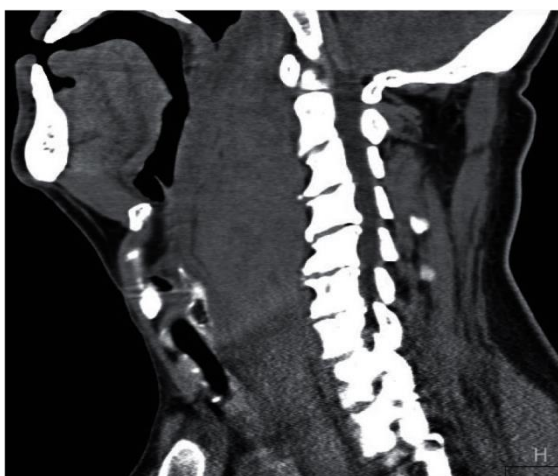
Computed tomography of the neck of 15.10.17: there is a heterogeneous soft-tissue formation with fairly even contours, which occupies almost the whole pharyngeal space, descending into the posterior mediastinum, along the esophagus, pushing back surrounding tissues and deforming the larynx and trachea
